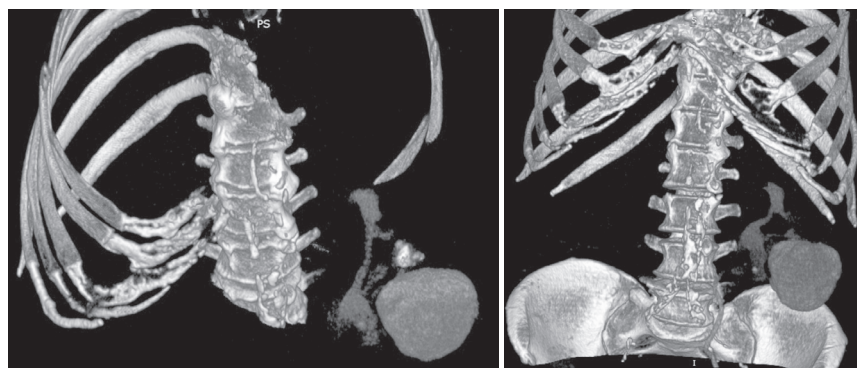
Multispiral computed tomogram of the kidneys (3D reconstruction). Large diverticulum of the calyx of the left kidney
